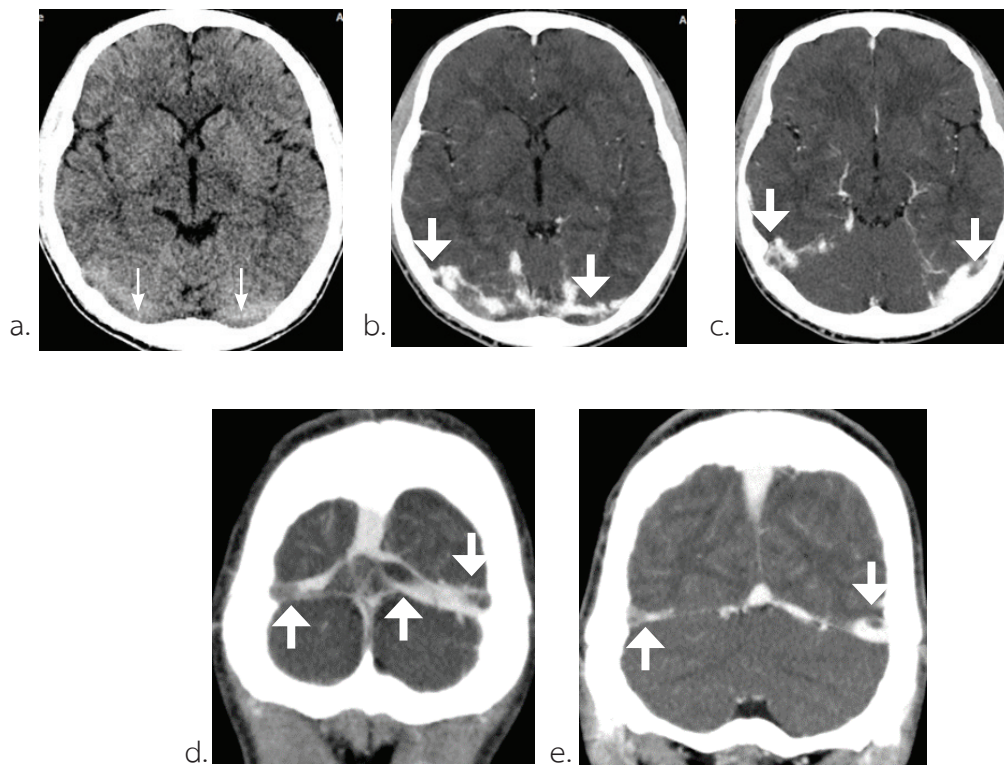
The computed tomography (CT) of the brain
